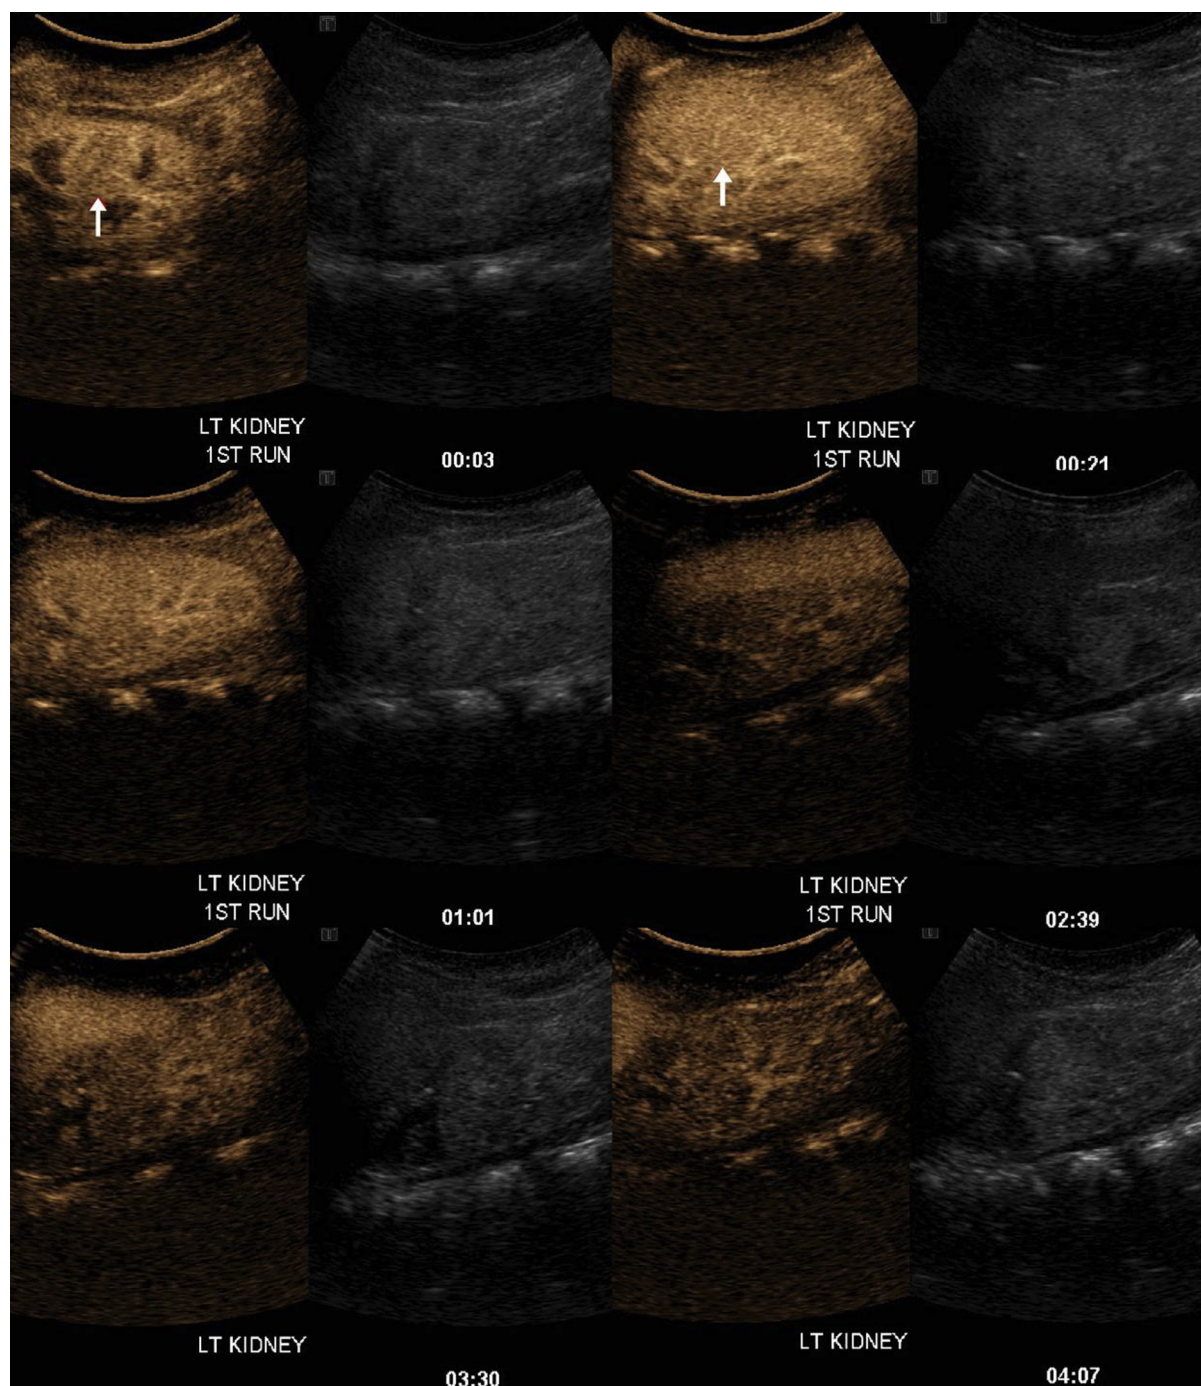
Pseudotumor. A 15-year-old girl, with incidental findings of a nonspecific mass on bedside US. Noncontrast-enhanced US shows an area of apparent altered echogenicity (arrow) in the interpolar region of the kidney, which is suspicious for a possible mass lesion. Post-contrast-enhanced US shows prompt and homogeneous enhancement in this area, with similar enhancement to the rest of the kidney, with no abnormal enhancement or washout, thus proving this to be normal renal tissue, likely to be prominent Column of Bertin. US = ultrasound.
